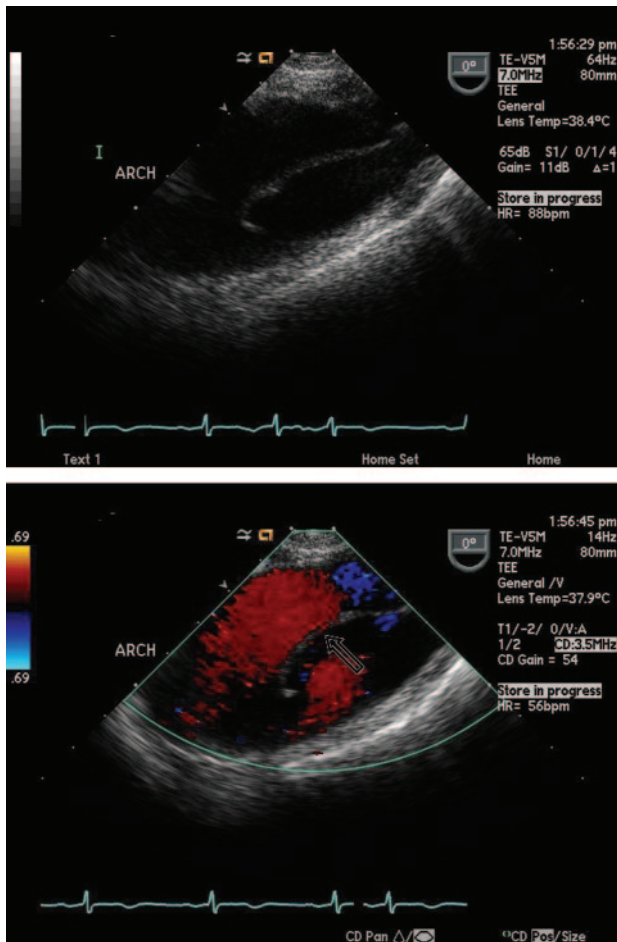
Arch aneurysm with dissection flap. Top, Arch dissection, 2-dimensional view. Bottom, Arch dissection (arrow) with color-flow Doppler margination.
